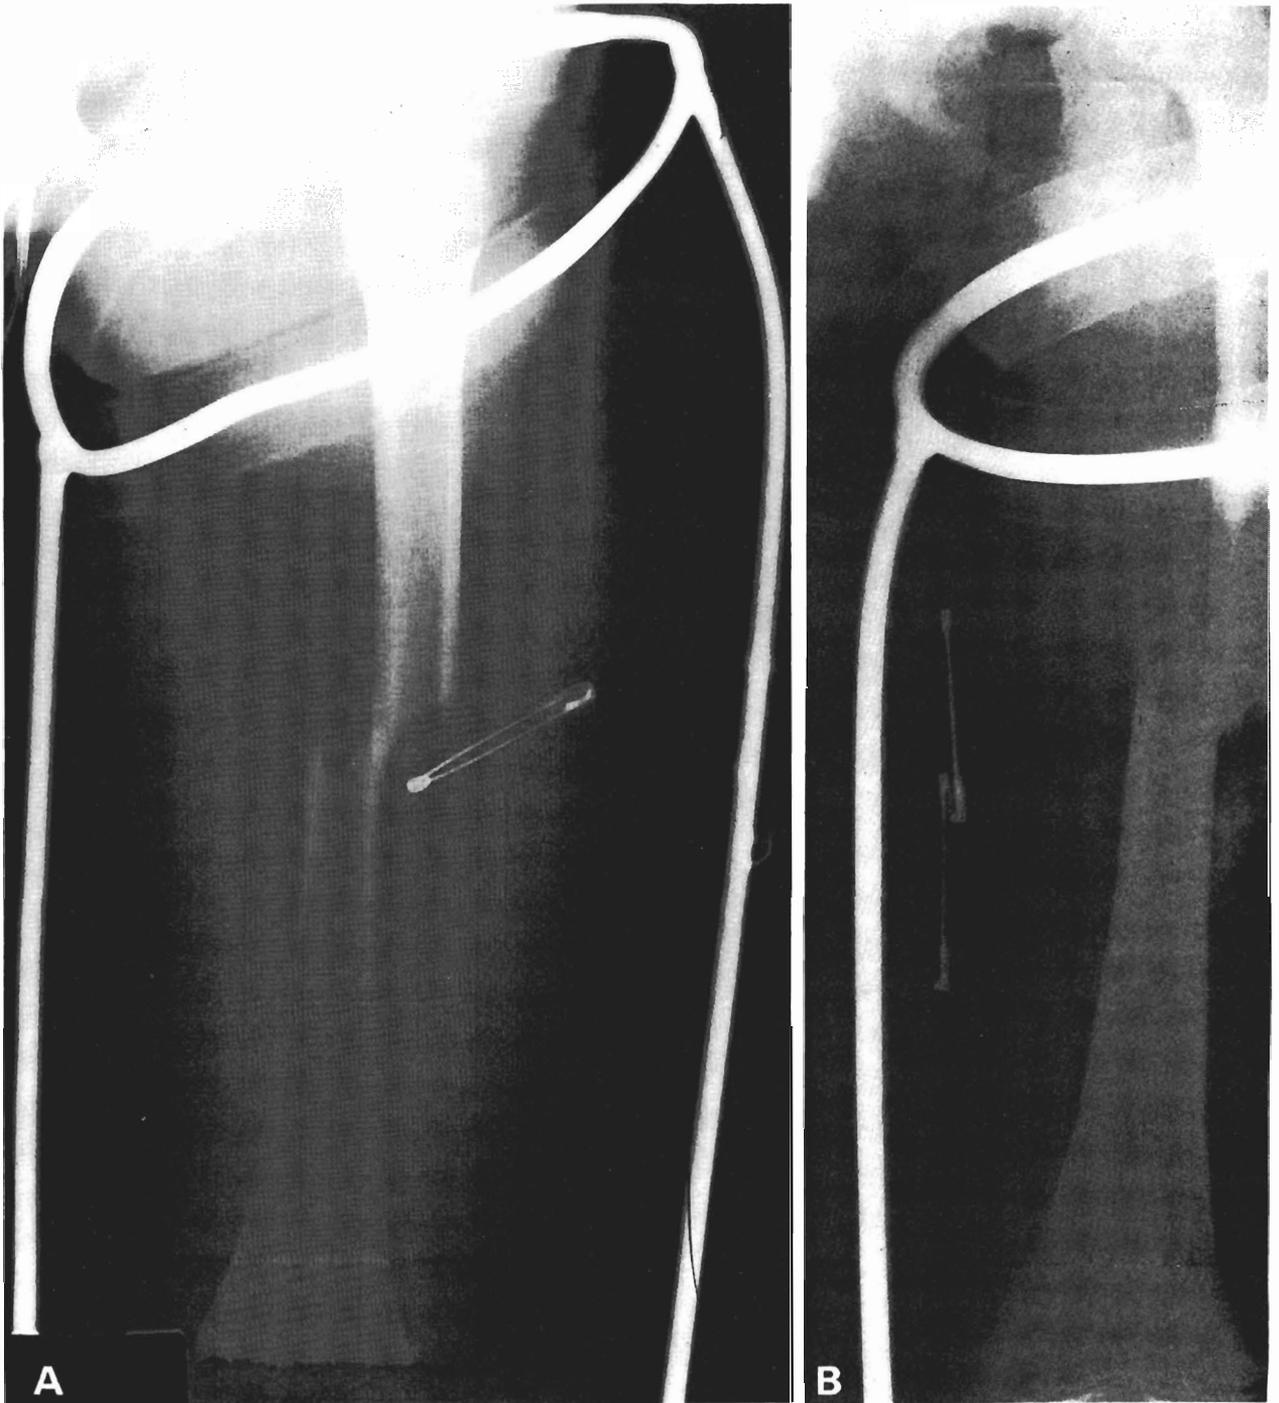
A typical fracture of the midshaft of the femur in a boy aged 10 years. (A) Initial appearance. Note that the diagnosis was made on clinical signs and the splint was applied before radiographs were taken. (B) At 17 days the fracture is clinically united and ready to go into a spica. (C) At 10 weeks. (D) The lateral view shows that the normal anterior bow of the femur has been maintained.
